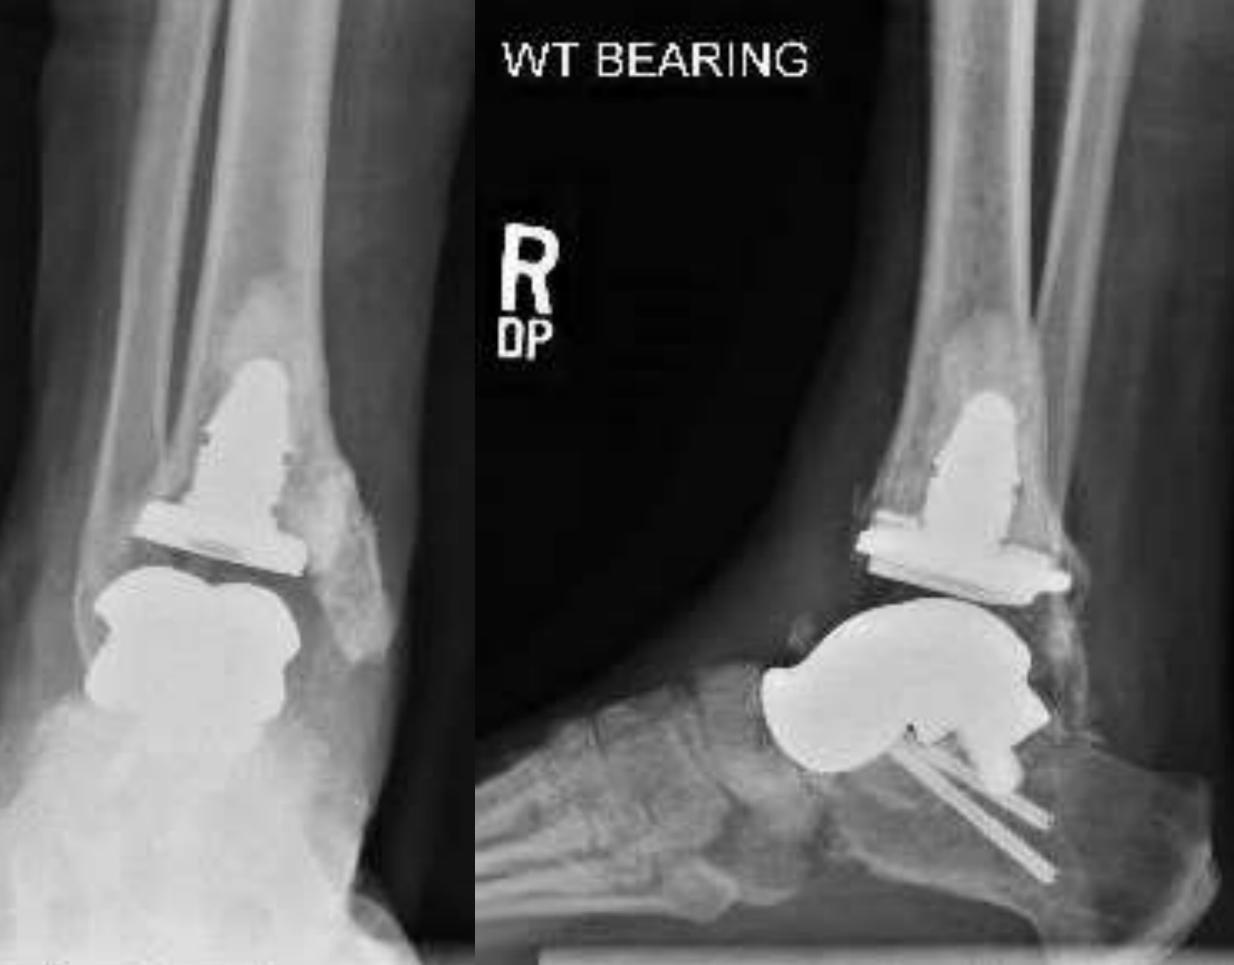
AP and lateral radiographs approximately 2 years status post talar
